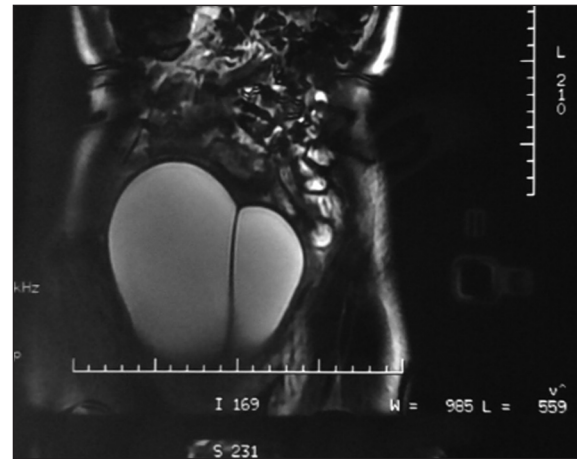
MRI showing incomplete bladder duplication
